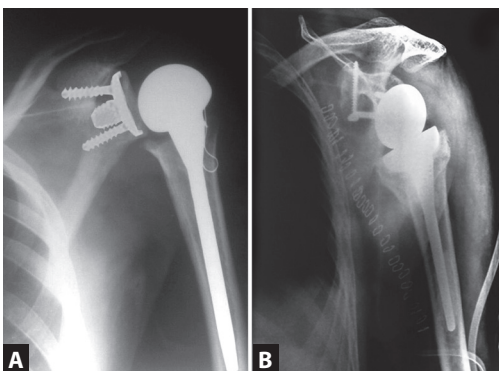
X-ray: Total shoulder arthroplasty: (A) Conventional; (B) Reverse shoulder (Courtesy: Dr Anand Shankar)
